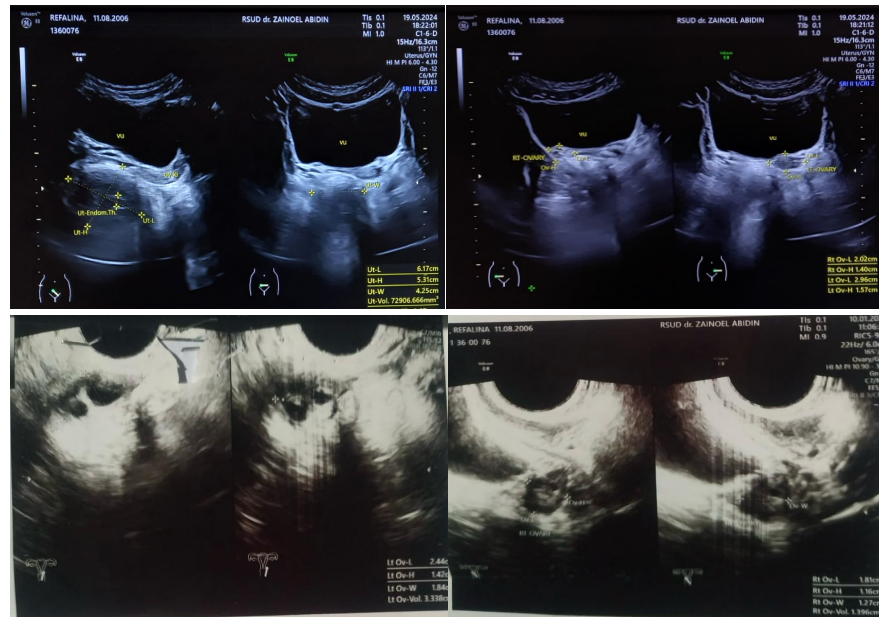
Ultrasound examination
